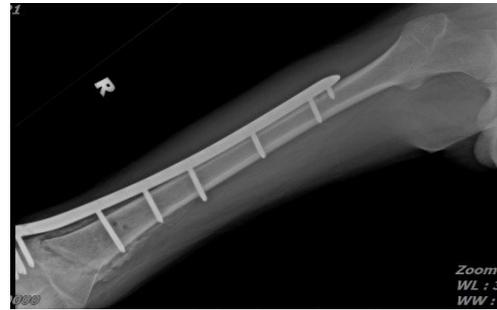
Right femur radiograph on admission
